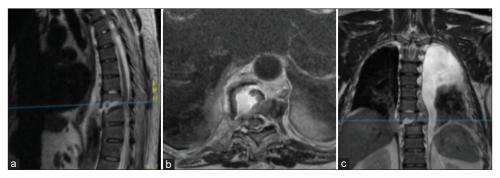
Magnetic resonance imaging T2 (a) Sagittal view (b) Axial view (c) Coronal view. It evidence lesion type C T8-T9.
